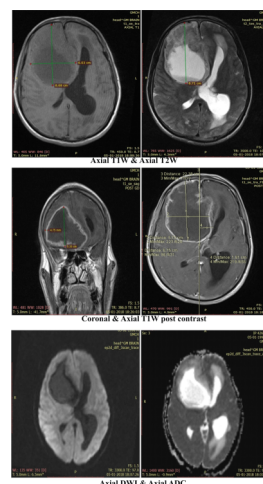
Large well defined irregularly margined mass right frontal region appearing heterogeneously hyperintense on T2/FLAIR and hypointense on T1 with nodular wall contrast enhancement. Lesion shows significant perilesional edema, effacement of right lateral with significant midline shift & periventricular CSF seepage. There is no restriction on DWI
